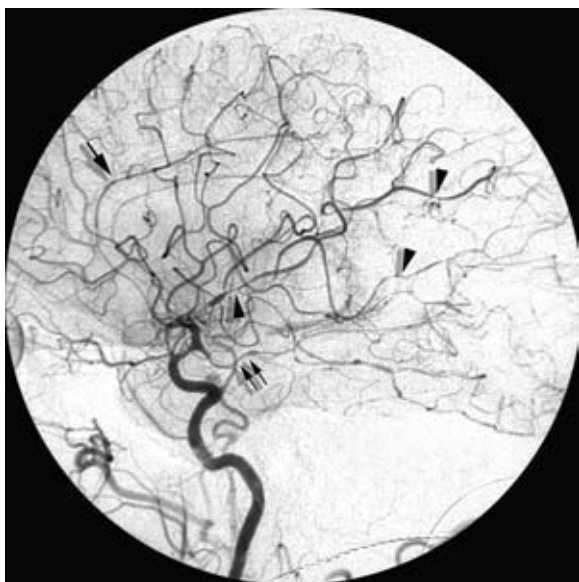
Postpartum RCVS treated with endovascular angioplasty and spasmolytic infusion. A 10-day postpartum patient in her mid-twenties was admitted with severe headache, mental status changes, and evidence of mild subarachnoid hemorrhage on CT. No aneurysm was identified. Her declining condition prompted repeated angiographic evaluation and eventual endovascular treatment of the proximal vasospastic vessels with balloon angioplasty and infusion of papaverine. The pattern of RCVS involvement of the middle cerebral artery (arrowheads) is multifocal and segmental, whereas that of the anterior cerebral artery (single arrow) and fetal posterior cerebral artery (double arrow) is more severe and generalized. Her clinical outcome was good.
